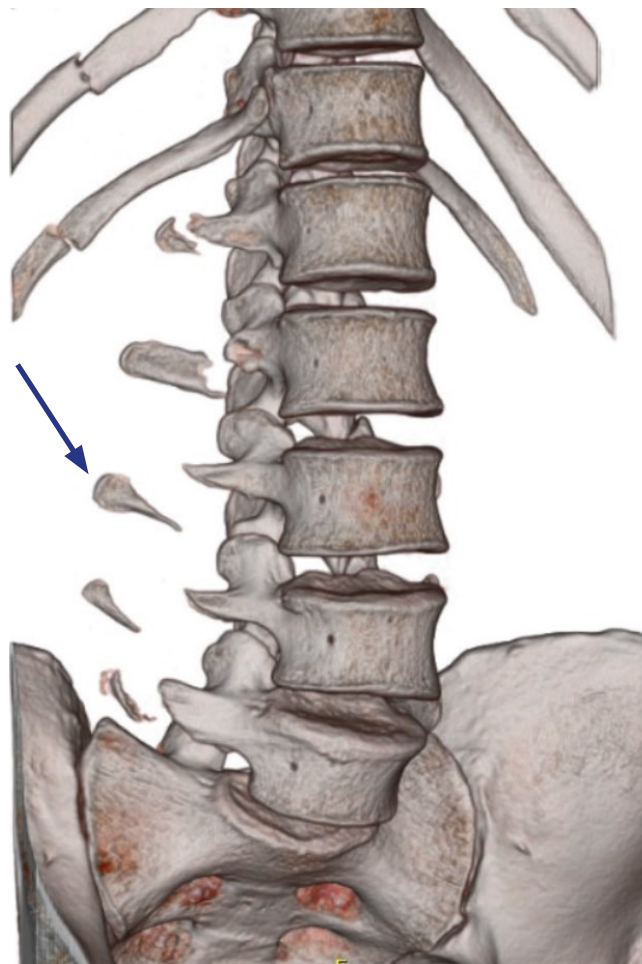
Three-dimensional CT showing inferior rib and L1–L5 transverse process fractures on the right side (black arrow).
